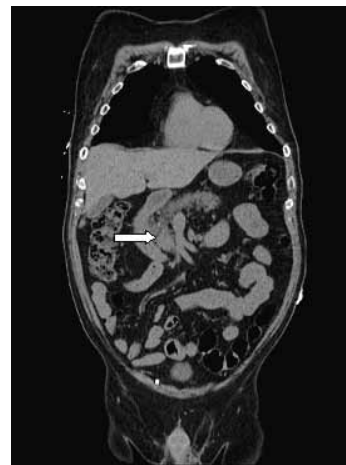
Coronal computed tomography image of the chest, abdomen, and pelvis. The arrow reveals a 1.7-cm × 2.4-cm mass at the uncinate process.
